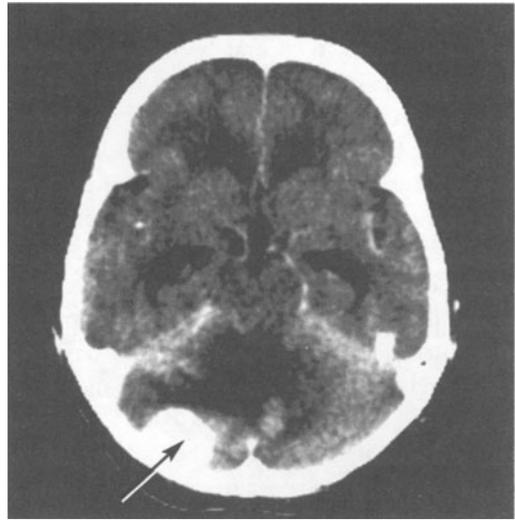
Hemangioblastoma of superficial superior and posterior right cerebellar hemisphere. CT scan indicated a densely enhancing mass (arrow) with considerable surrounding edema and cyst formation extending into the opposite cerebellar hemisphere and hydrocephalus. This 60-year-old white female had a several month history of increasing headaches, exacerbated by straining at stool, laughing or any head movement, a sense of dizziness, a sense of instability in walking and a normal neurologic examination. Angiogram demonstrated a vascular mass supplied by the posterior inferior cerebellar and superior cerebellar arteries, as well as meningeal branches. Dr Bernard Stone removed the tumor with relief of symptoms.
